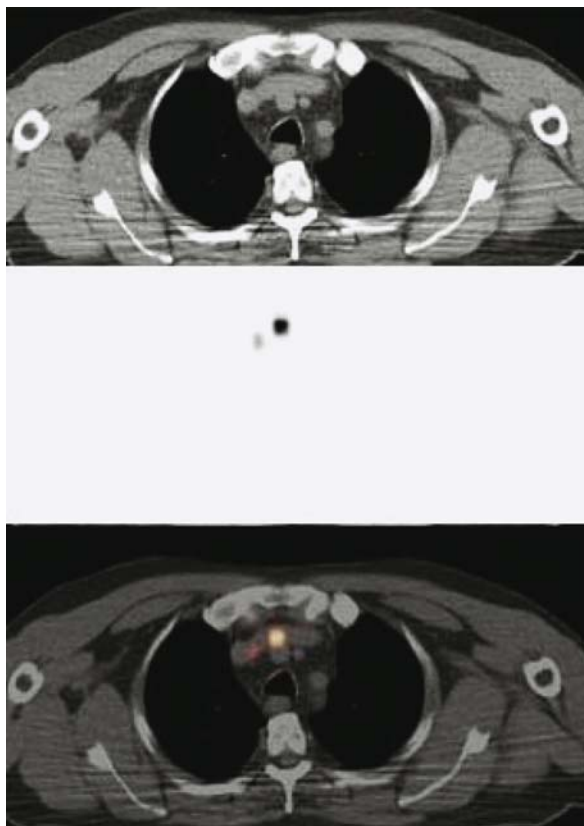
^{124}I PET (A), CT (B), and PET/CT (C) acquired 24 h after oral administration of 85 MBq pathological tracer uptake mediastinally, representing mediastinal micrometastases close to the aorta
